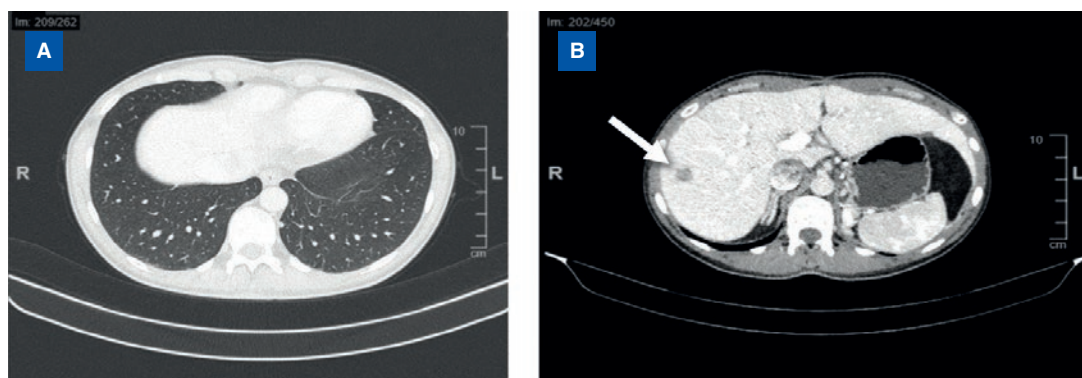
Computed tomography scans showing nodules in the lungs (A) and mass in the liver (B, arrow) after three cycles of doxorubicin plus dacarbazine, three surgeries, and 12 sessions of radiotherapy (November 2019).
